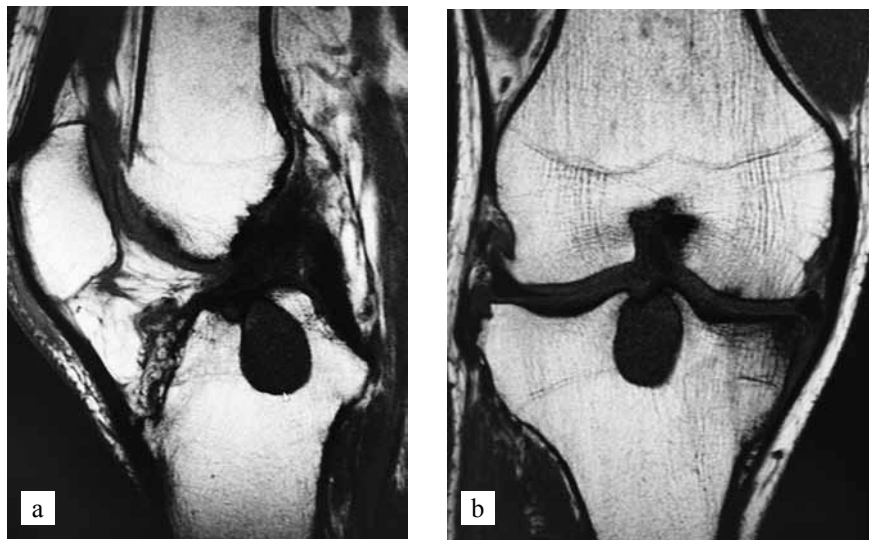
Magnetic resonance imaging (MRI) of the knee. Tibial cyst. a) sagittal plane. b) frontal plane
